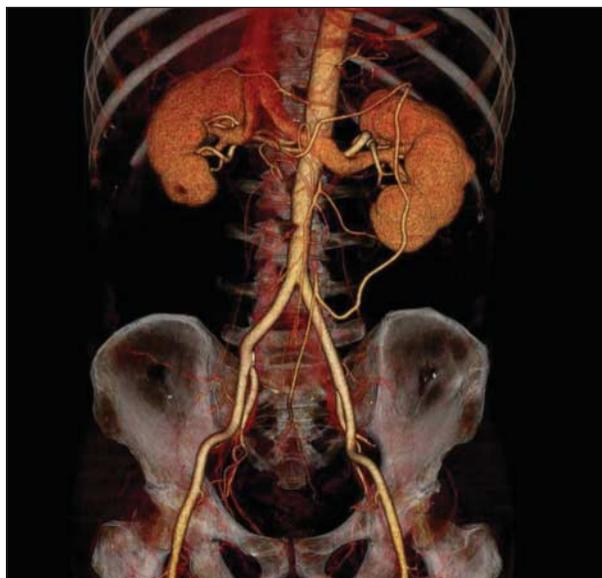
Three-dimensional reconstructed images of the computed tomographic scan revealed occlusions at the origins of the celiac axis and superior and inferior mesenteric arteries but maintained blood flow in their distal lesions.
